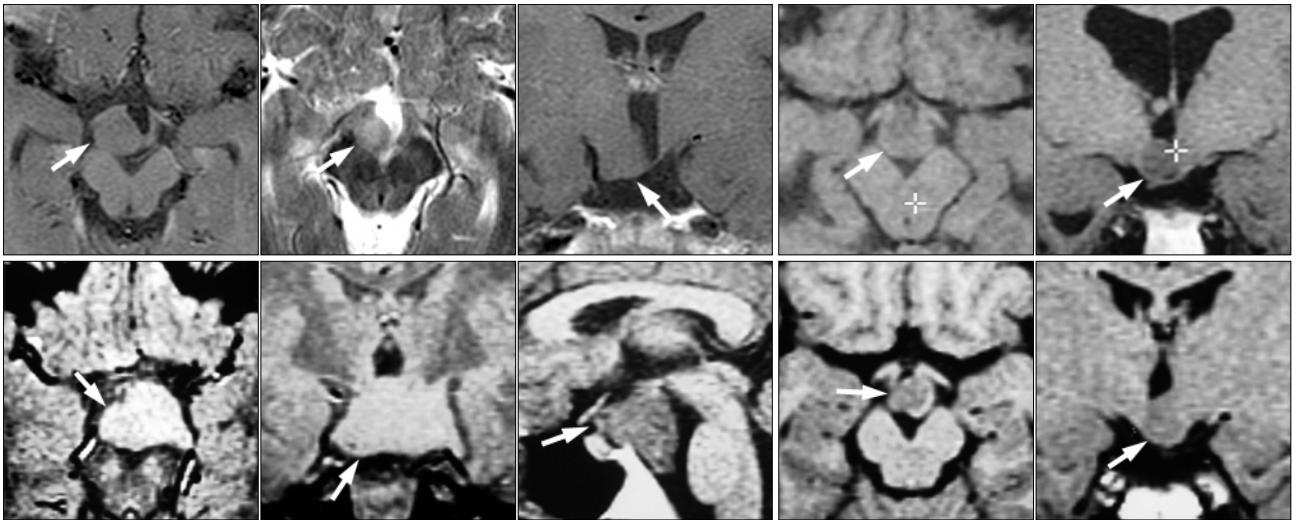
MR images of sessile type hypothalamic hamartoma with intractable gelastic seizure (arrows : hypothalamic hamartoma).
